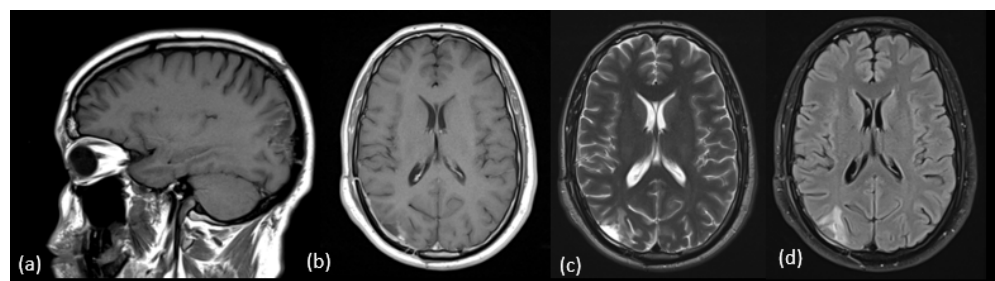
Postoperative sagittal T1-weighted (a), postcontrast T1-weighted axial (b) T2-weighted axial (c) and, axial flair (d), confirmed complete excision of the tumor.
